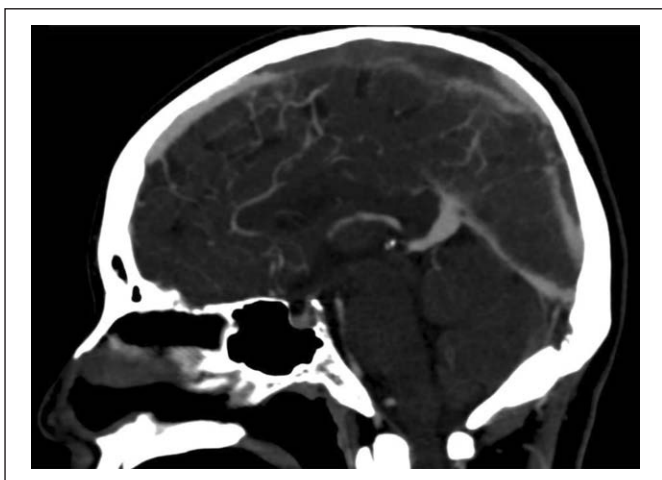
Brain CT scan showing the cerebral vein thrombosis extended to the upper longitudinal sinus and cortical veins.
